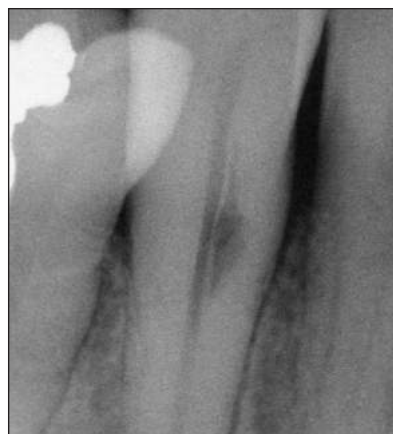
An extracanal invasive resorption can be identified lateral to but parallel with the canal space. No radiographic evidence can be identified of a resorption hole at the root surface or the resorbed pathway from the periphery to the main focus of resorption. Small radiolucent projections (“spider legs”) extend from the main focus of the resorption.
